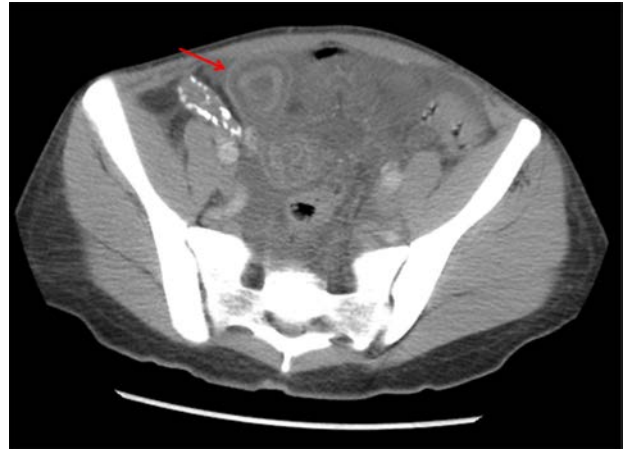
Computed tomography scan with intravenous contrast of the abdomen and pelvis. Small bowel target sign due to mural stratification and prominent circumferential edema of the bowel wall.
